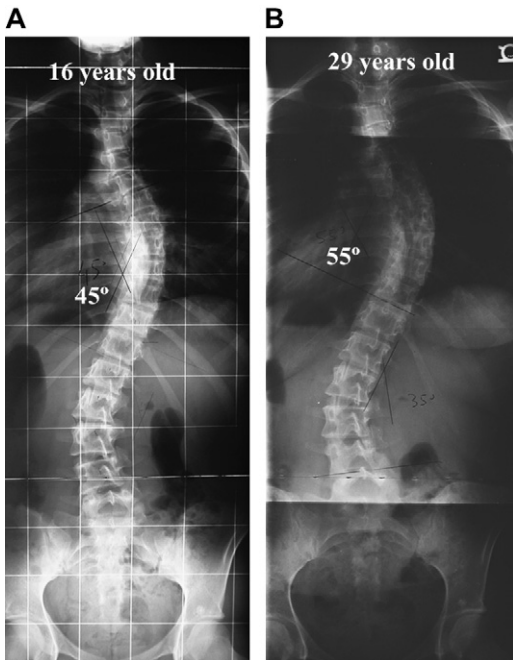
Progression of a right thoracic curve in a skeletally mature woman. (A) Standing radiograph of the patient at 16 years of age shows a 45° right thoracic curve. (B) Standing radiograph of the same patient at 29 years of age shows a 10° progression of the right thoracic curve over 14 years.
